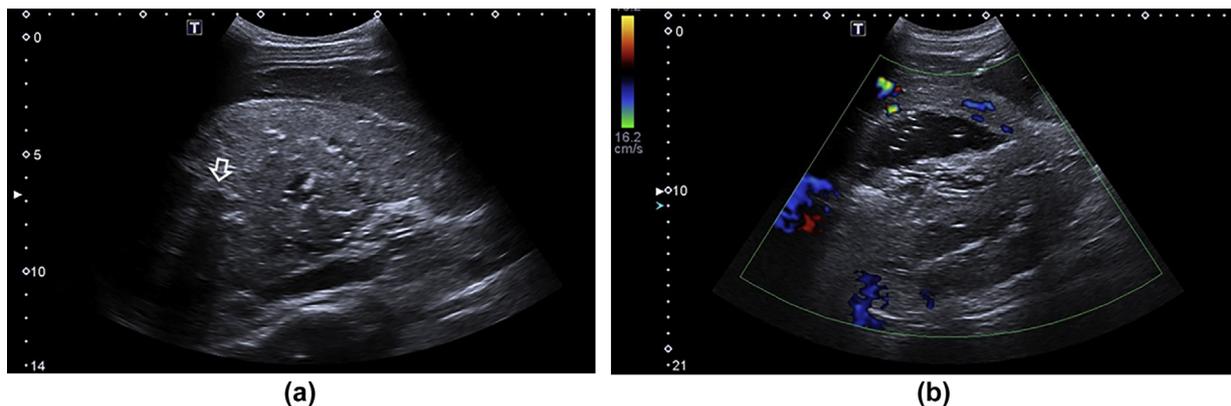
Sonographic appearances are broadly clustered into two main morphologies, those of a more (a) solid hyperechoic mass, often with indistinct margins and intralesional calcification (note internal acoustic shadowing (arrow) or more (b) pseudo-cystic with central hypoechoic components, internal debris and irregular/relatively non-vascular peri-lesional tissue on Doppler US. Both images demonstrate lesions in the right hepatic lobe, obtained intercostally.
